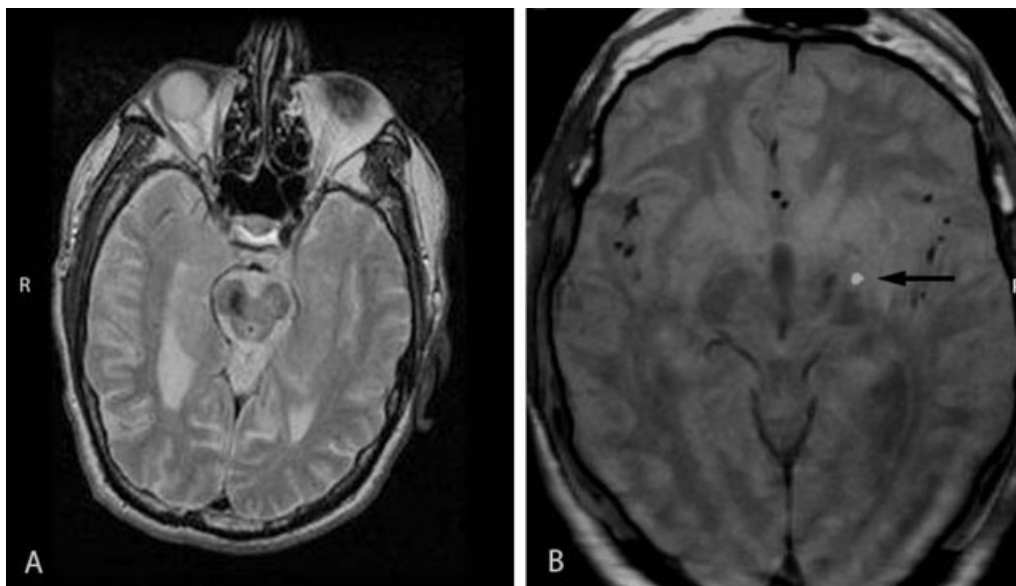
(A) MR scan showing an oval shaped focus of low signal in the right side of the midbrain with extension into the substantia nigra and subthalamic nucleus. (B) Fused CT/MRI image showing the position of the active contact (arrow).
